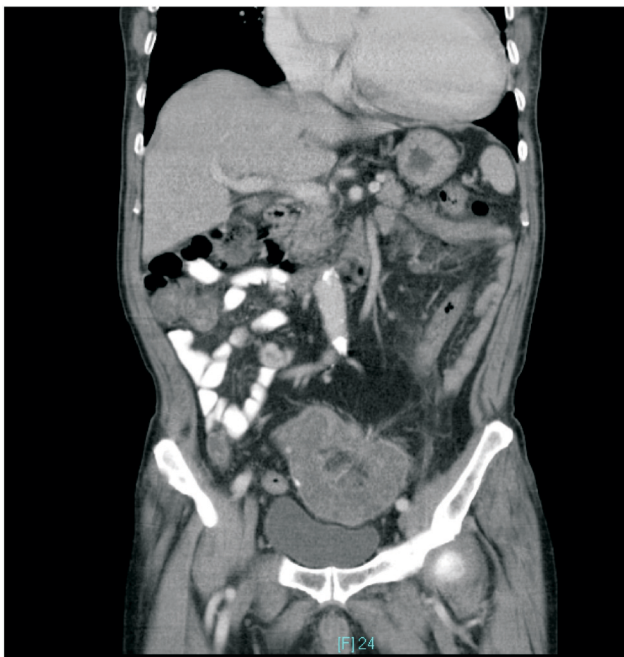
CT image shows a classic double-ring, target lesion, suggesting colonic intussusception.
